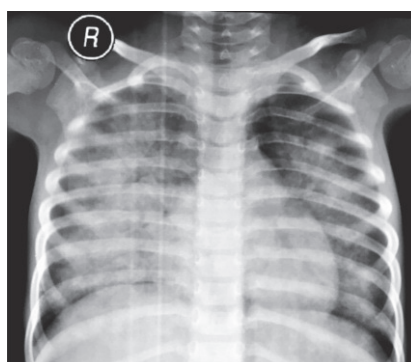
Chest X-Ray of patient showing bilateral consolidation which was taken after 25 days of ingestion
